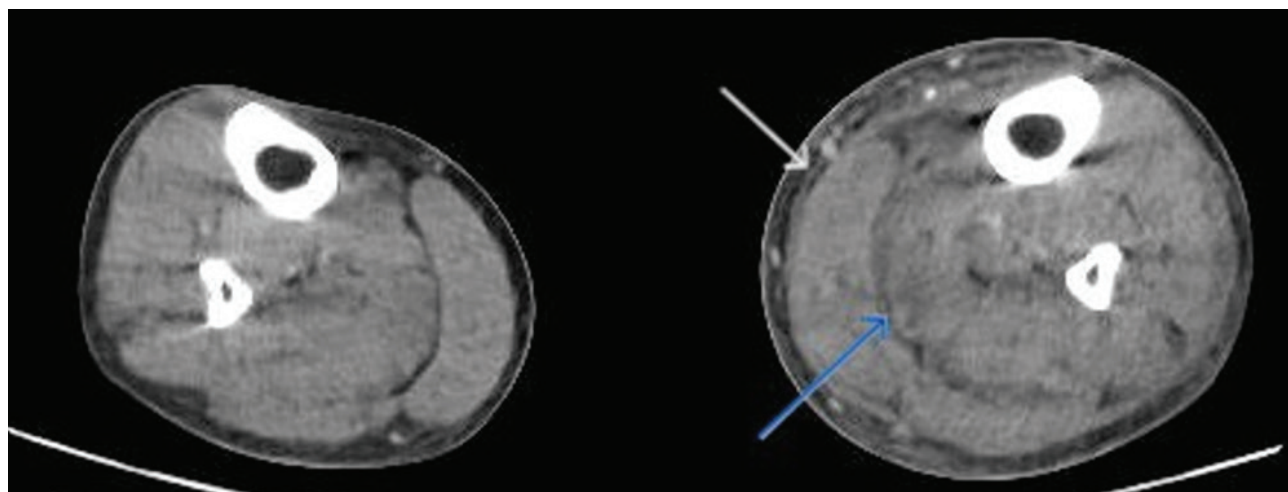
CT showing subcutaneous edema and fascial fluid in left calf (arrow), consistent with deep infection. Left: Normal right leg. Right: Affected left leg. The top white arrow indicates subcutaneous edema; bottom blue arrow shows fluid between gastrocnemius and soleus muscles.
